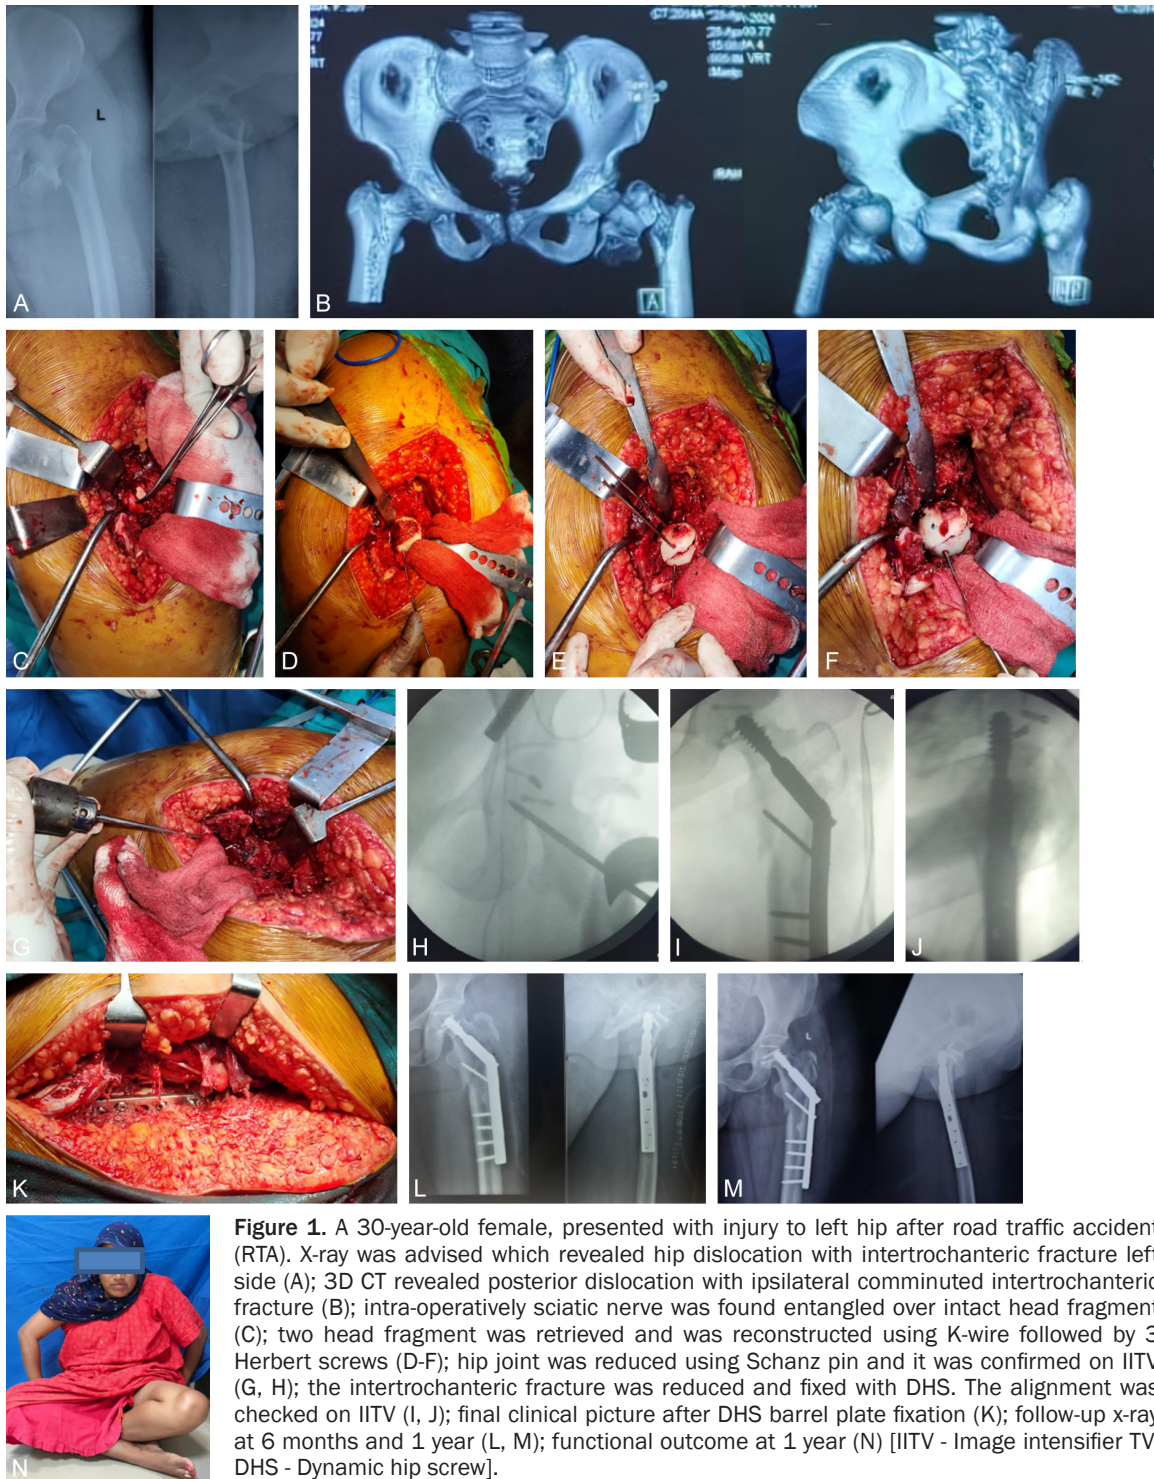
A 30-year-old female, presented with injury to left hip after road traffic accident (RTA). X-ray was advised which revealed hip dislocation with intertrochanteric fracture left side (A); 3D CT revealed posterior dislocation with ipsilateral comminuted intertrochanteric fracture (B); intra-operatively sciatic nerve was found entangled over intact head fragment (C); two head fragment was retrieved and was reconstructed using K-wire followed by 3 Herbert screws (D-F); hip joint was reduced using Schanz pin and it was confirmed on IITV (G, H); the intertrochanteric fracture was reduced and fixed with DHS. The alignment was checked on IITV (I, J); final clinical picture after DHS barrel plate fixation (K); follow-up x-ray at 6 months and 1 year (L, M); functional outcome at 1 year (N) [IITV - Image intensifier TV, DHS - Dynamic hip screw].
